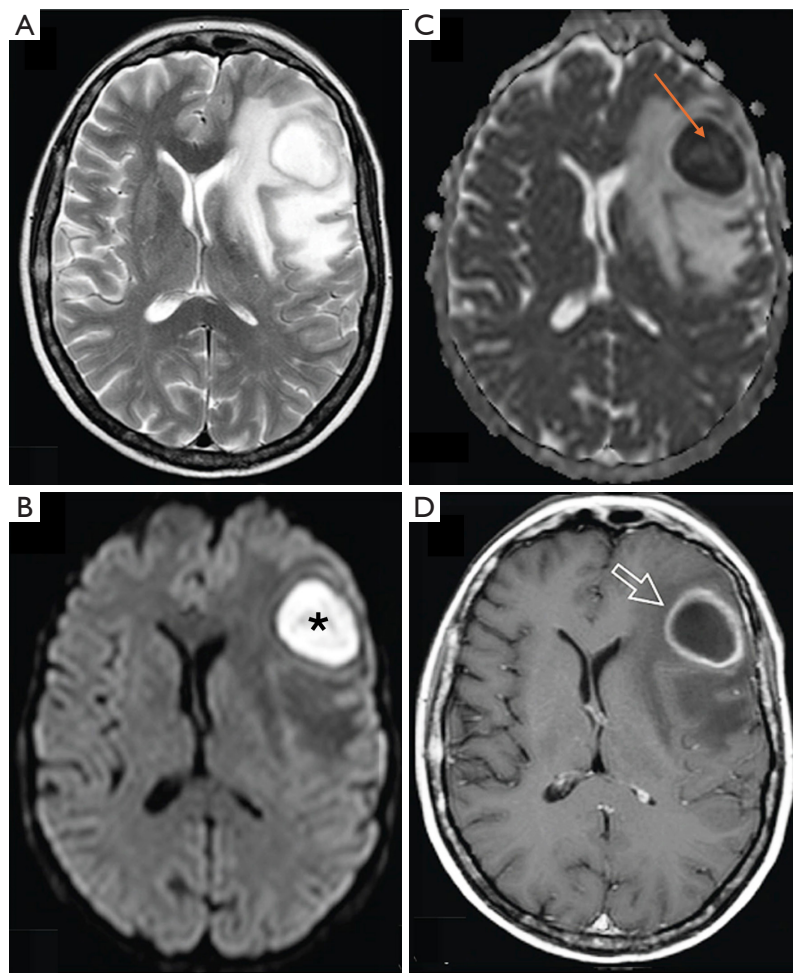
MRI of a 37-year-old woman with a pyogenic abscess in the left frontal lobe (A) T2 weighted image; (B) DWI; (C) ADC map; (D) contrast enhanced T1 weighted image. The central component of the lesion shows high signal on T2 weighted image, high signal on DWI (asterisk in B) and low value on ADC map (C, lower than the brain tissues, arrow). Arrow in (D) denotes a ring enhancement after contrast agent administration. It appears unreasonable that the abscess content has a so low ADC measure. Adapted from Feraco *et al.* (1). ADC, apparent diffusion coefficient; DWI, diffusion-weighted imaging; MRI, magnetic resonance imaging.
